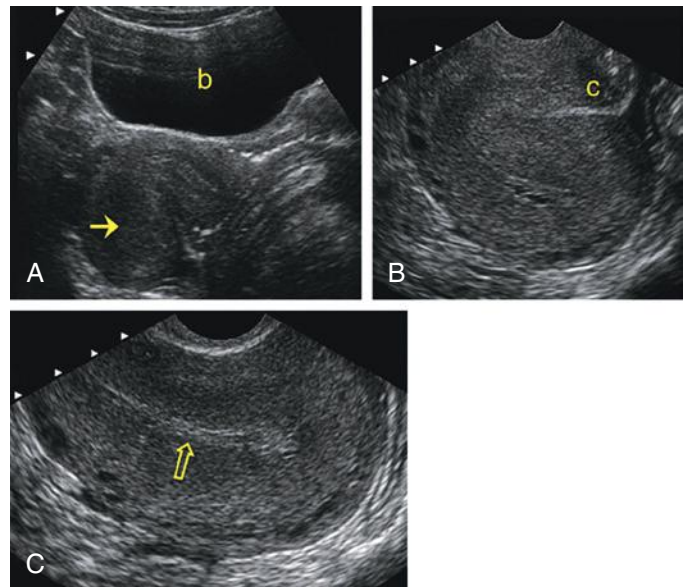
Improved visualization of the uterus with transvaginal imaging. A, Longitudinal transabdominal sonogram of a retroflexed uterus performed through a full urinary bladder (b). The endometrial canal (arrow) in the body of the uterus is not well seen as it lies parallel to the ultrasound beam. B, Transvaginal sonogram of the same patient. The cervix (c) is interposed between the transvaginal probe and the body of the uterus. This gives suboptimal visualization of the myometrium and endometrial canal. C, Transvaginal sonogram of the body and fundus of the uterus after the probe has been repositioned beyond the cervix and angled posteriorly. The probe now lies immediately adjacent to the retroflexed uterus, providing much improved visualization of the endometrium (open arrow).
